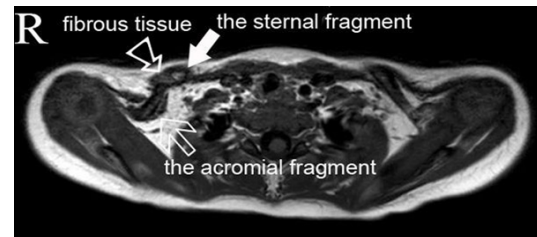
The preoperative Magnetic Resonance Imaging (MRI) horizontal scans of T1 weighted of the clavicle showed a discontinuous clavicle with fibrous tissue interposition (upper hollow arrow). The discontinuous clavicle including the sternal end (solid arrow) and the acromial end of congenital pseudarthrosis of the clavicle (lower hollow arrow).
